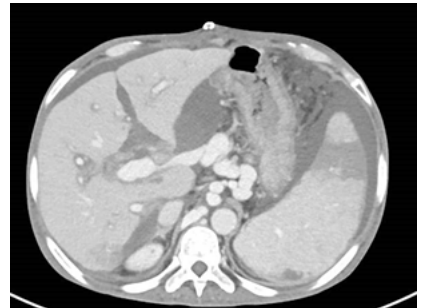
abdominal computed tomography showing patent PV-LGV anastomosis (arrow).
